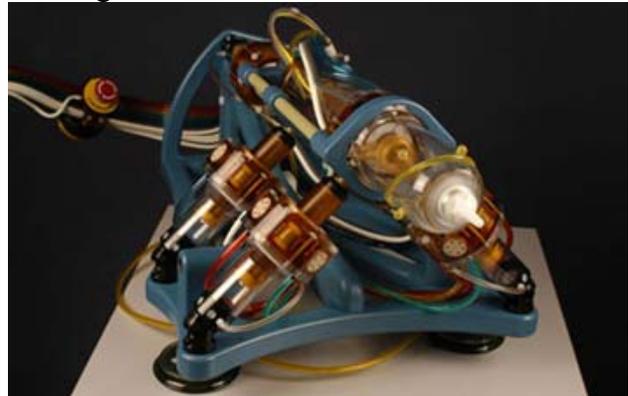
MrBOT parallel robotic MRI compatible structure
